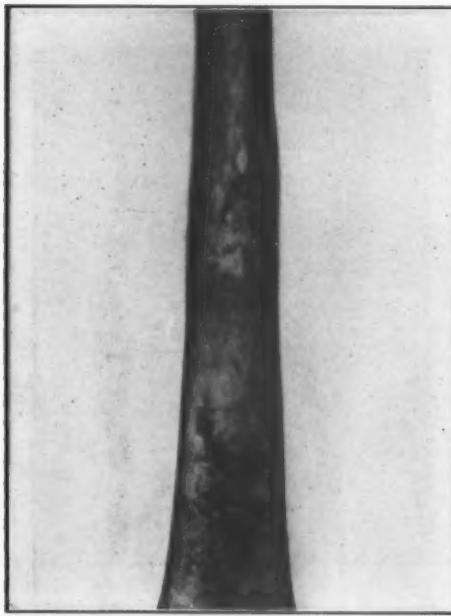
Path. No. 25505 (IX). Perosteal sarcoma of lower end of femur. No x-ray evidence of periosteal tumor, only of the marrow invasion. See page 201.
